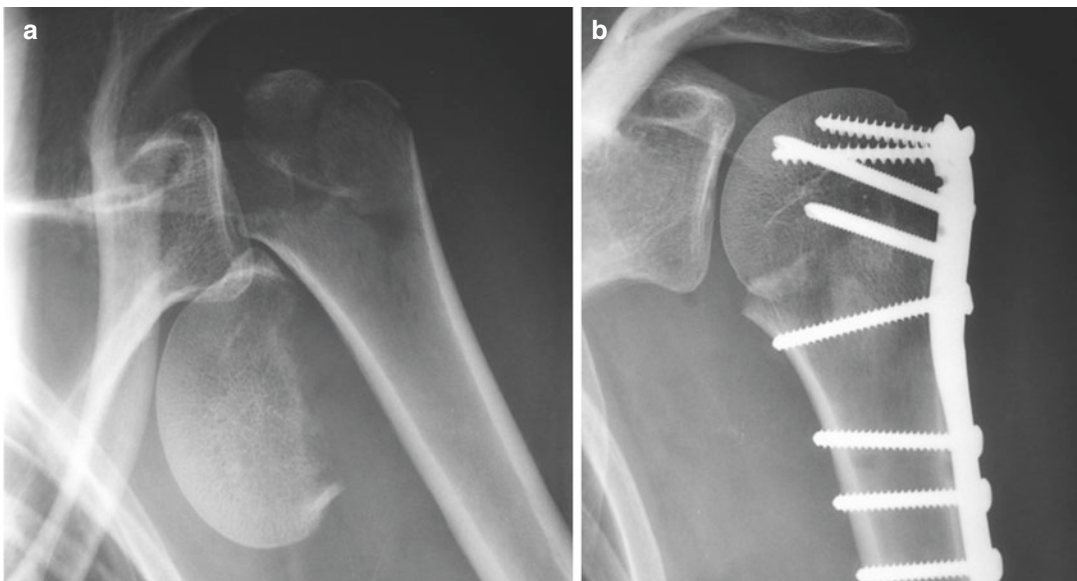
fracture-dislocation of the humeral head (anatomical neck) (a) preoperative and (b) postoperative X-rays
